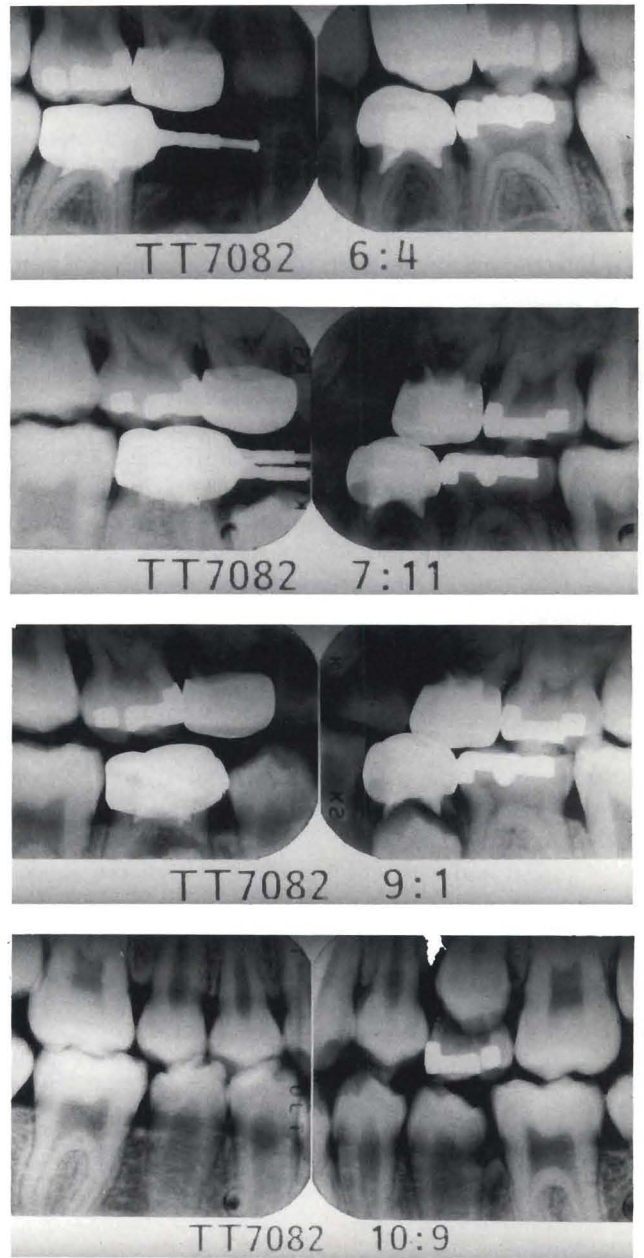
Representative bitewing series of patient where electrourgically pulpotted teeth (#1, L and T) were followed to exfoliation. All 3 teeth were treated with a pulpotomy at age 5 years, 8 months. Postoperative radiographs were taken at age 6 years, 4 months (a); 7 years, 11 months (b); 9 years, 1 month (c); and 10 years, 9 months (d).
